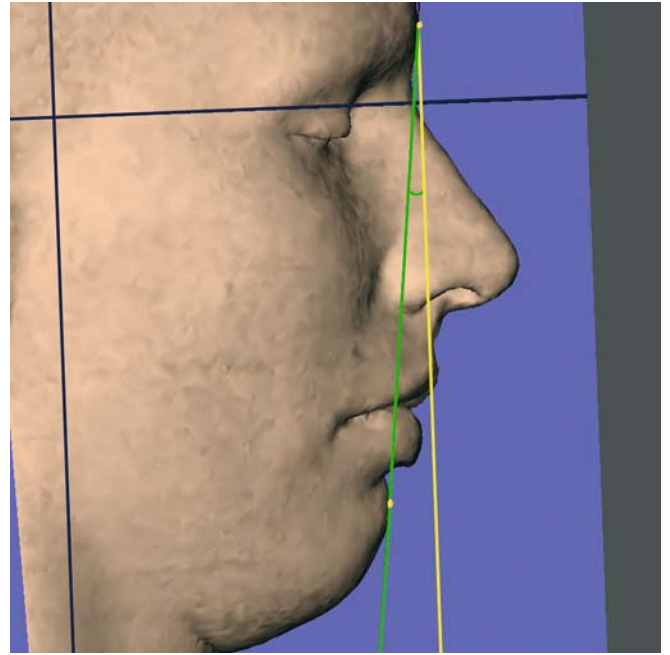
The inclination of the general profile line from the vertical plane, $g-pg / y$ -plane, is a projected angular soft tissue measurement on the median (z) 3-D cephalometric reference plane (3-D CT, soft tissues, patient K.C.)
